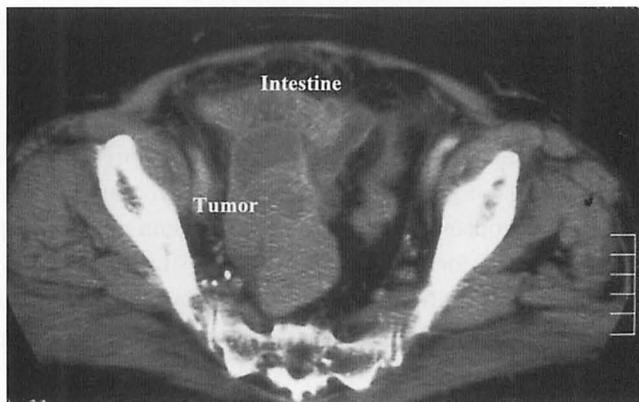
CT of case 1 revealed a pelvic tumor, 7×4 cm in size. Tumor was composed of solid, homogenous part and foci of cystic lesion. The small intestine was adjacent to the tumor.
